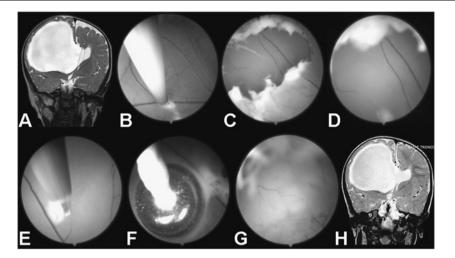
A 3-month-old baby girl with a history of intraventricular hemorrhage; pre-operative coronal T2-weighted MR image shows a right isolated ventricle with contralateral shift of the septum pellucidum (a). A standard precoronal access to the right ventricle allows the septum to be approached and visualized well: the first wall is fenestrated by means of monopolar coagulation due to its thickness (b). A
